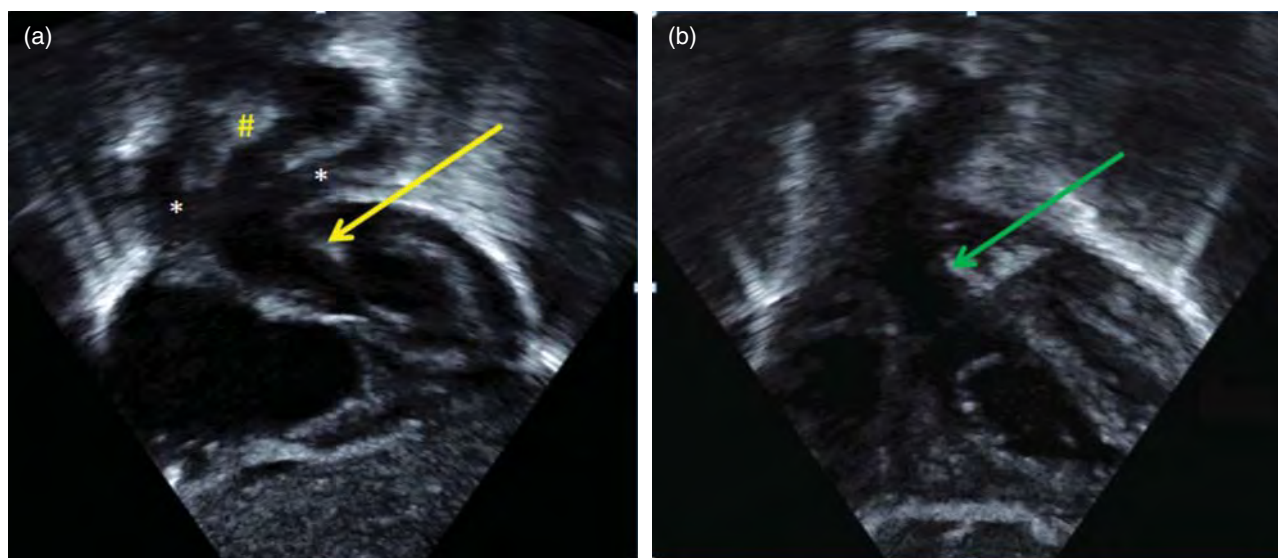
(a) Echocardiogram: subcostal coronal view showing the pulmonary artery arising from the left ventricle (yellow arrow). The early branching of the main pulmonary artery into the branches is seen (*), as well as the presence of a large patent ductus arteriosus (#). (b) Subcostal coronal view in more anterior plane, showing the aorta arising from the right ventricle (green arrow). Note the lack of fibrous continuity between the open tricuspid valve and the closed aortic valve.
